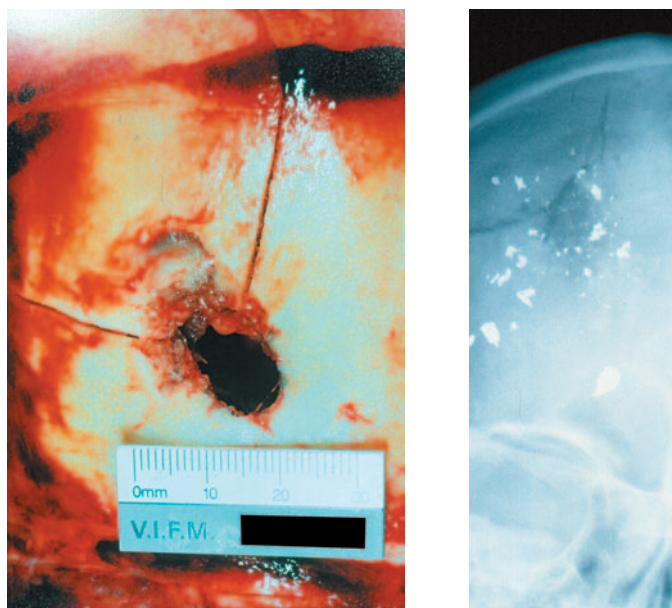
Scalp peeled back (left) revealing a keyhole-like defect to the outer bony table. There are two radial linear fractures. At right, X-ray of corresponding area.
